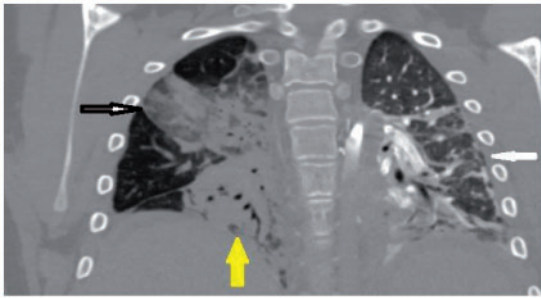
Patient 2: Coronal post-contrast arterial phase computed tomography image of the chest demonstrating ground-glass appearance (black arrow), segmental parenchymal collapse (yellow arrow), and interstitial thickening (white arrow).
